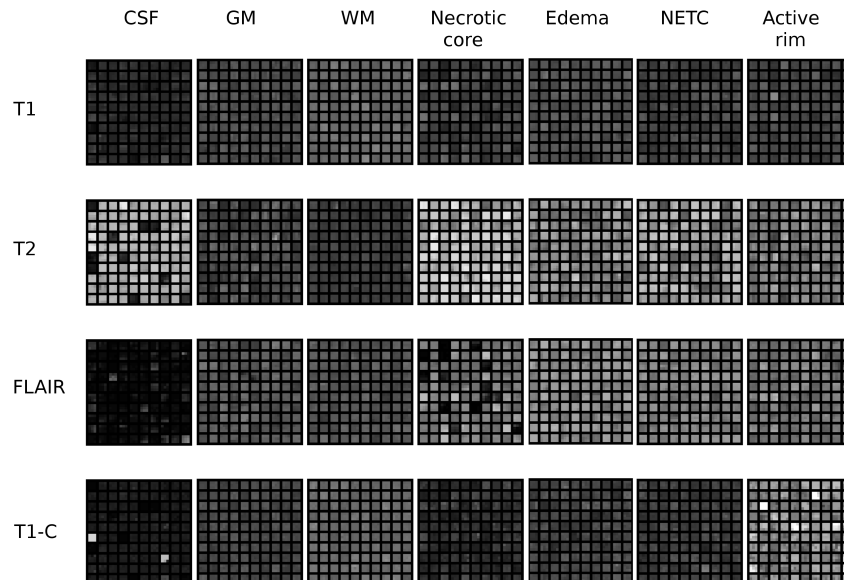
2D slices of randomly sampled 3D multi-channel patches. From left to right: the different MR channels (T1, T2, T2-FLAIR, contrast enhanced T1). From top to bottom: cerebrospinal fluid (CSF), grey matter (GM), white matter (WM), necrotic tumor core, edema, non-enhancing tumor core (NETC), and active rim.
